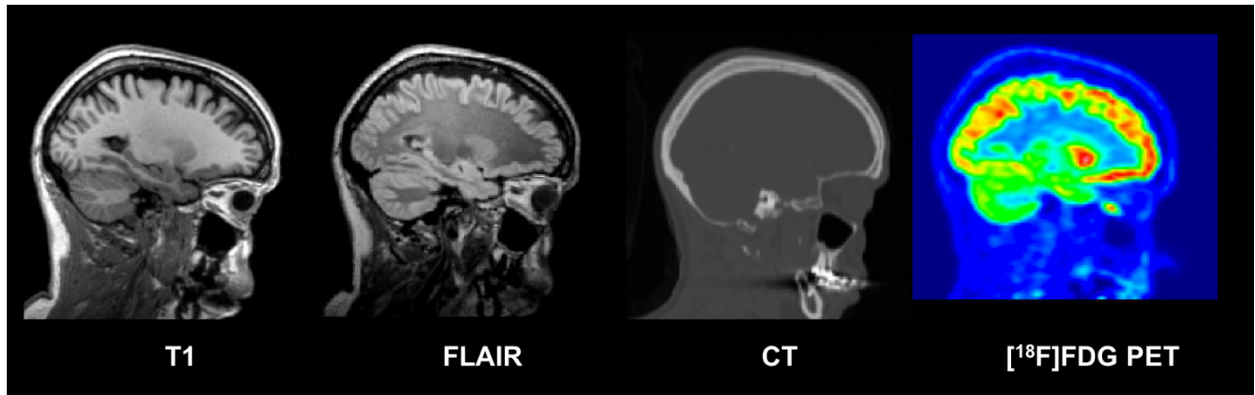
Example of coregistered T1 MRI, FLAIR MRI, CT and [¹⁸F]FDG PET images (sagittal plane) for one subject of the database
